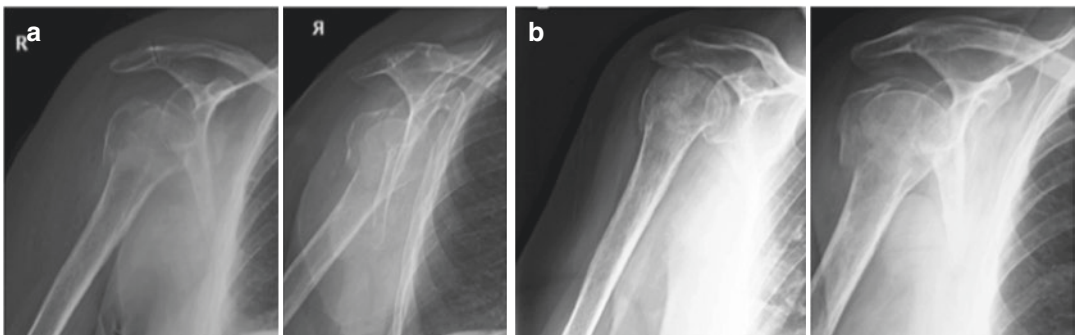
84-year-old female with displaced proximal humeral fracture: (a) First X-ray evaluation after the fall. (b) Radiographical outcome: fracture healed after conservative treatment. Eight weeks follow-up
